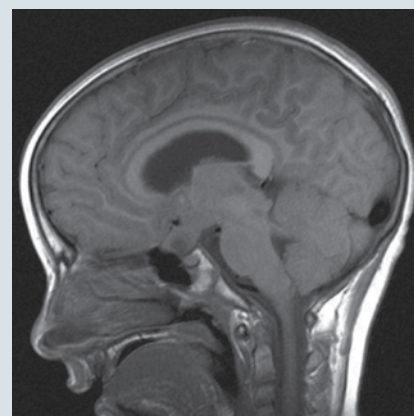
Chris’s MRI showing a large central mass at the optic chiasm.
